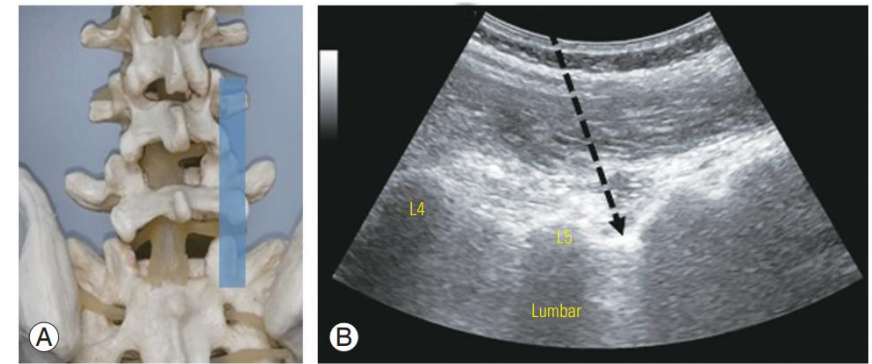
(A) Spine model with intended ultrasound window. (B) Ultrasound view of the posterior sagittal paravertebral plane demonstrates ultrasound-guided lumbar spine paravertebral nerve root injection. The intended needle placement (arrow) is performed in an in-plane direction, with the needle tip penetrating the thin hyperechoic intertransverse ligament.
